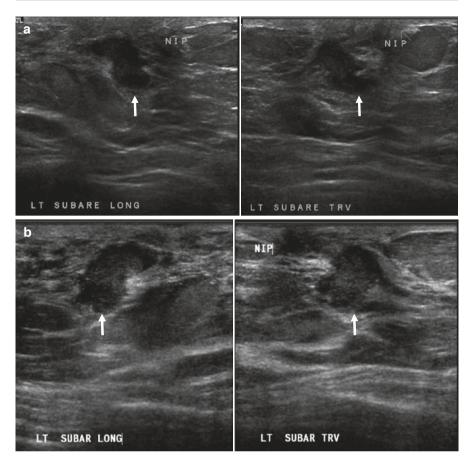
Lactational abscess. (a) 41-year-old woman treated empirically with two courses of antibiotics with no decrease in size of a palpable mass and continued decrease in milk production from this side. Targeted ultrasound shows an irregular complex solid (iso-/hyperechoic) and cystic mass and surrounding edema. The internal echoes were mobile in real-time. (b) Ultrasound-guided needle aspiration is done, draining the fluid collection to completion. (c) Follow-up ultrasound 2 weeks later was normal (not shown).
